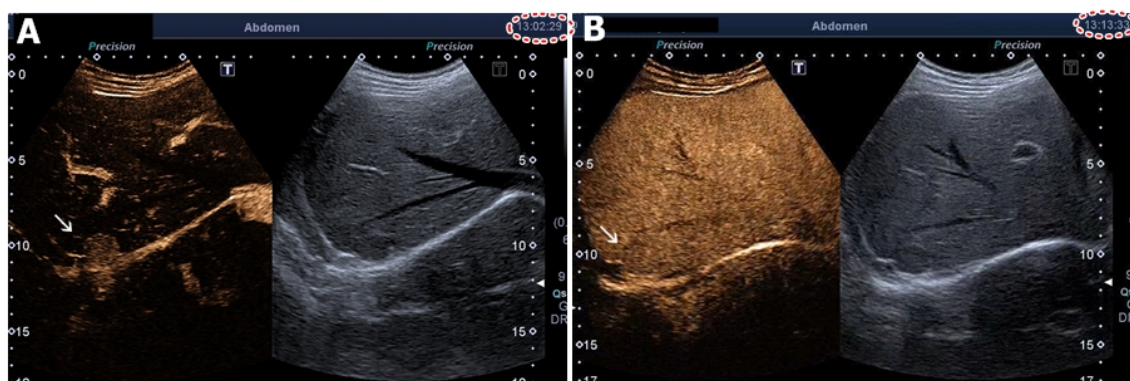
A. Gray-scale B-mode and contrast-enhanced ultrasound (CEUS) in arterial phase (00:17 s of exploration). Image shows premature hyperenhancement with respect to the liver parenchyma. B. Gray-scale B-mode and CEUS in late venous phase (03:32 s of exploration). The lesion presented faint washout with respect to the bud parenchyma.
